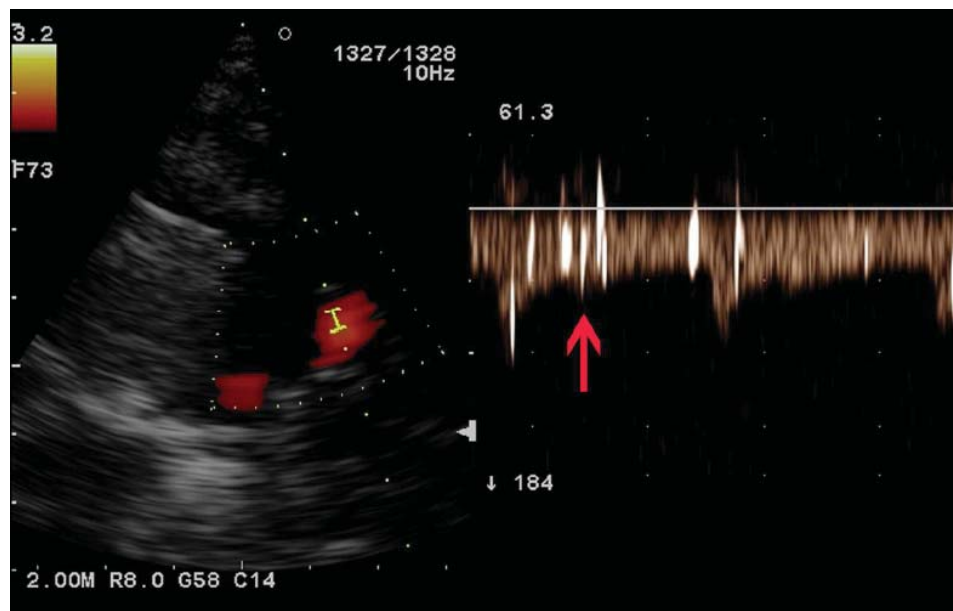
Arterial gas emboli visualized by transcranial color-coded sonography: post-dive arterial gas emboli apparent as high-intensity transient signals (hits - arrow) in the Doppler spectrum in the middle cerebral artery in a diver with a patent foramen ovale³
